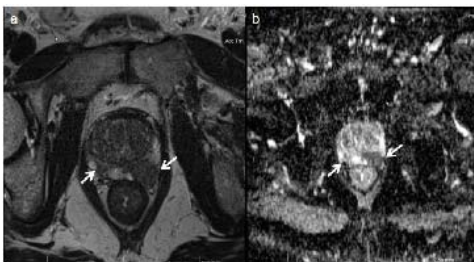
Axial T2-weighted image (a) depicts a large mass in left peripheral zone with extracapsular extension and a smaller lesion in right peripheral zone. Both show decreased ADC on ADC map (b) – proven high grade tumor on biopsy
